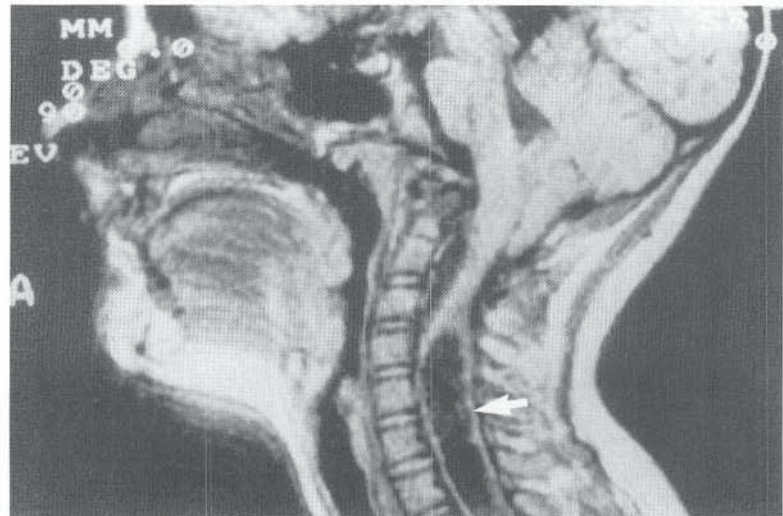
Diagnostic imaging of the spinal cord and canal is necessary in children with abnormal neurologic findings. MRI is the optimal study for assessing the neural axis. A large cervical syringomyelia (arrow) is evident on this MR image of the head and neck. (From Richards BS: Back pain in childhood and adolescence: the clinical assessment. *J Musculoskeletal Med* 1998;15:39.)
